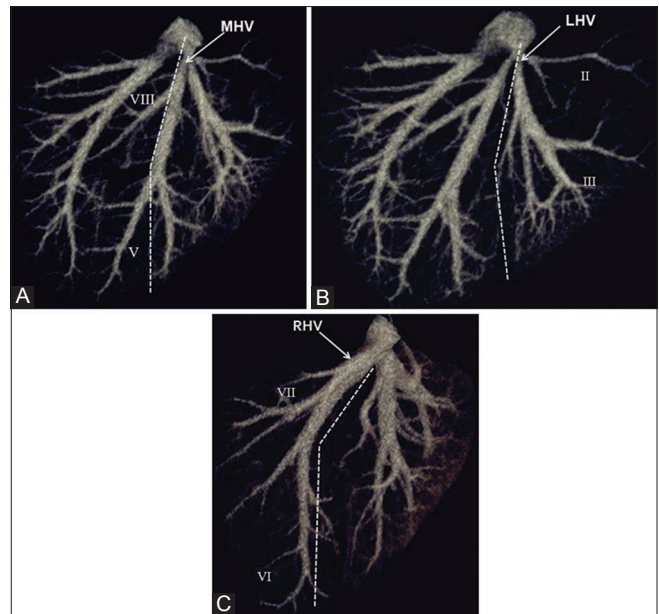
Hepatic segmental anatomy. Three dimensional (3D) volume rendered (VR) image from CT angiographic data shows various hepatic segments (except segment I)
